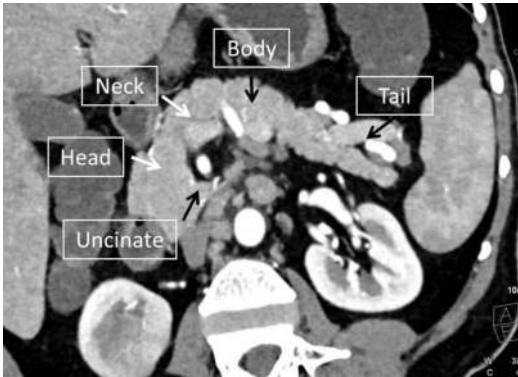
Oblique reformatted CT image showing cross-sectional anatomy of the pancreas
